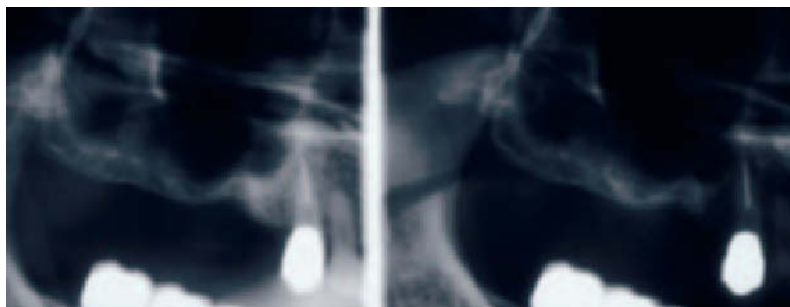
Radiograph of right posterior maxilla showing sinus cavity occupying the alveolar process.
